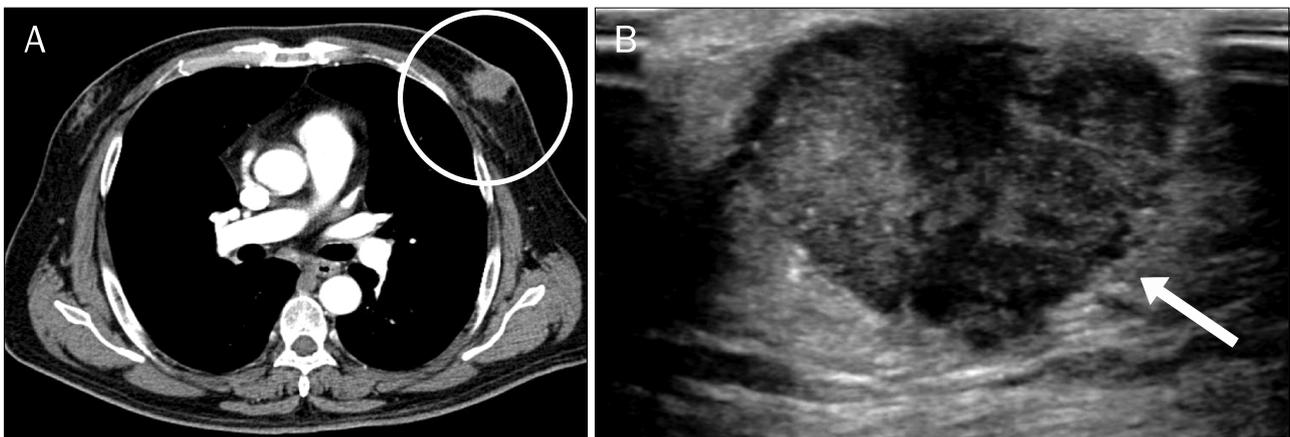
Radiologic findings of the patient. (A) Computed tomography showed low attenuated lesion with spiculated margin in the left breast (white circle). (B) Ultrasonographic scanning shows lobular hypoechoic mass of 3.2 cm in size including calcification on the left subareolar area (white arrow).
